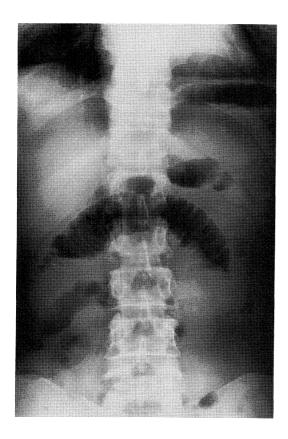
The findings of an abdominal X-ray film. The abdominal X-ray film showed niveau of the small intestine, the so-called "herring bone" sign.
